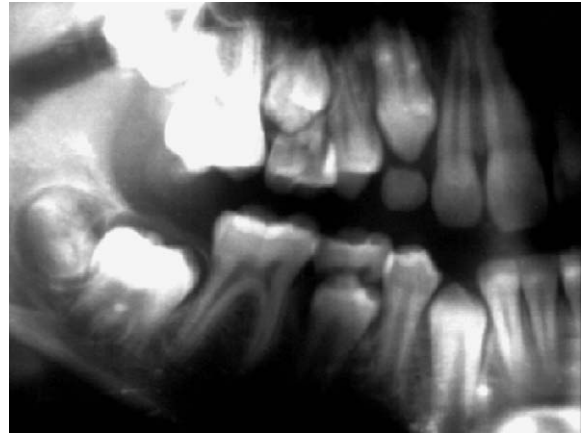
A radiograph with abnormal teeth appearance and poor image quality.
